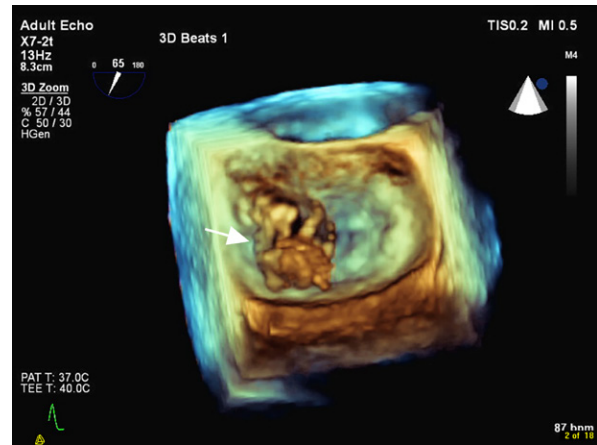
Transesophageal echocardiogram (3-dimensional zoom surgical view in systole) shows the ruptured papillary muscle fragment (arrow) prolapsing into the left atrium.
